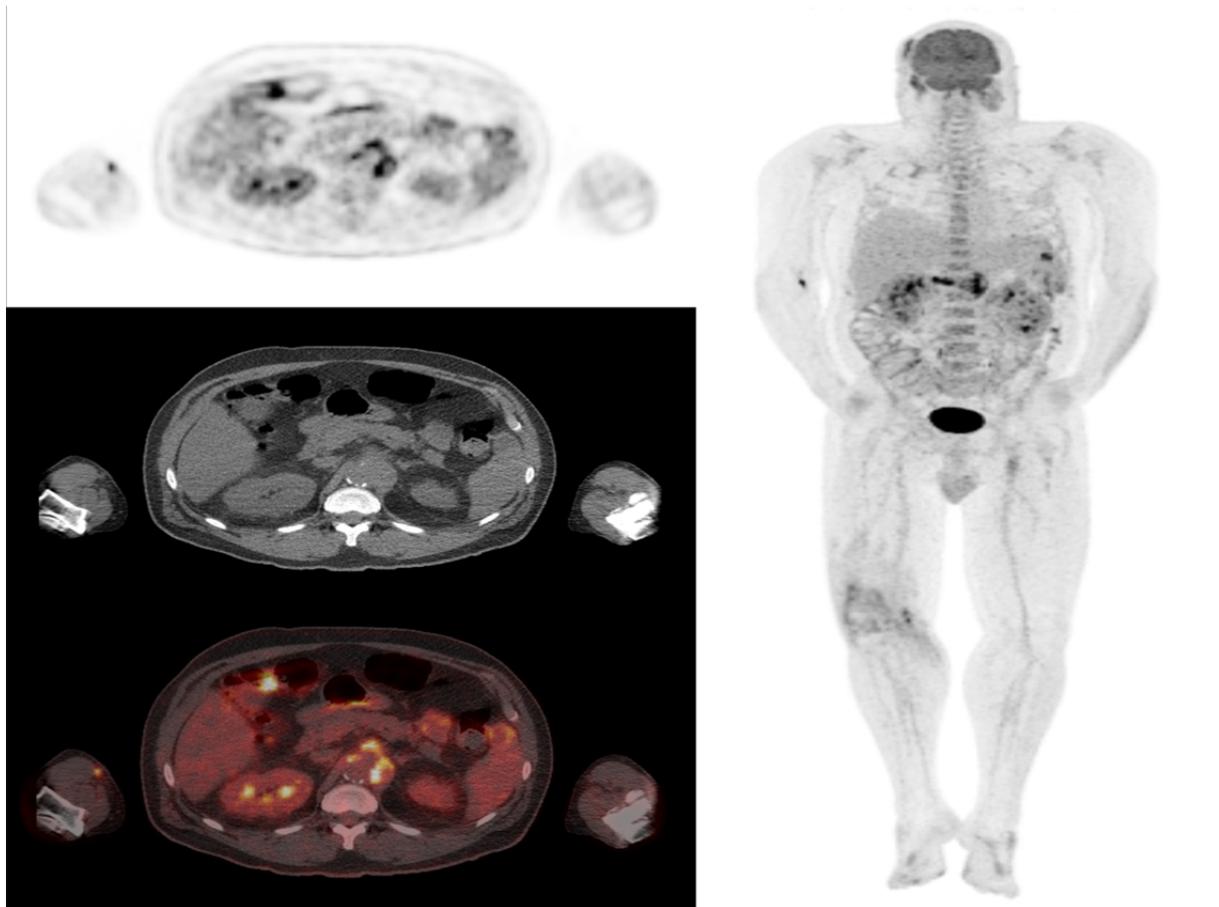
Transversal ^{18}F -FDG-PET/CT images at the level of the celiac trunk (left) and maximum intensity projection (MIP) image (right) of a 60-year-old man who was admitted because of a septic arthritis of his right knee.
